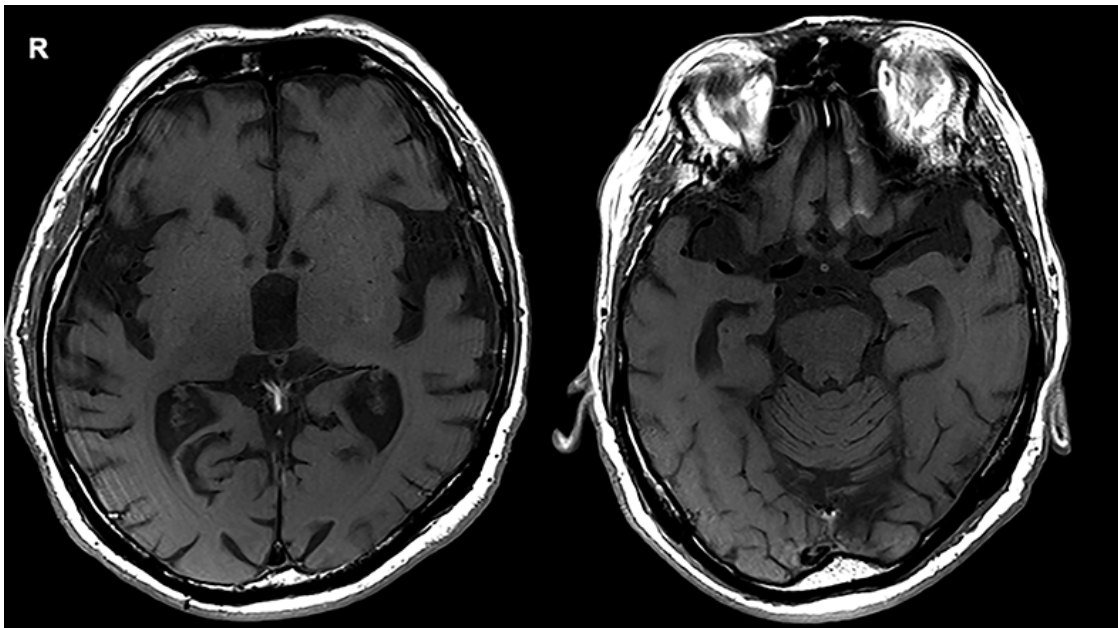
Brain magnetic resonance imaging (MRI) revealed relative preservation of the medial temporal lobe and atrophy in the bilateral perisylvian area.
